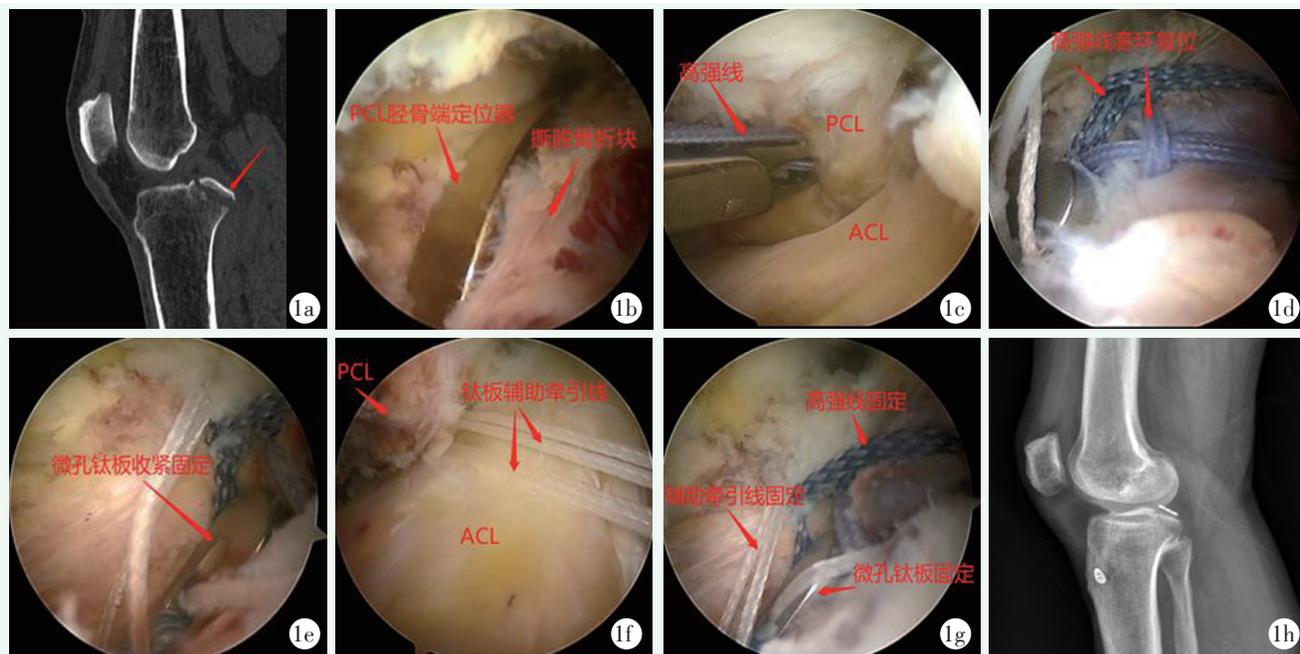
患者女性，40 岁。1a：术前矢状位 CT 平扫片示后交叉韧带胫骨止点部位撕脱骨折并移位；1b：PCL 胫骨定位器复位骨折块；1c：高强度线穿部分 PCL 入后关节腔；1d：双套环高强度线复位骨折块；1e：收紧固定微孔钛板；1f：钛板辅助牵引线拉入前关节腔环绕 PCL 打结固定；1g：镜下见高强度线、微孔钛板、辅助牵引线三重固定；1h：术后矢状位 X 线片示骨折对位对线良好。
